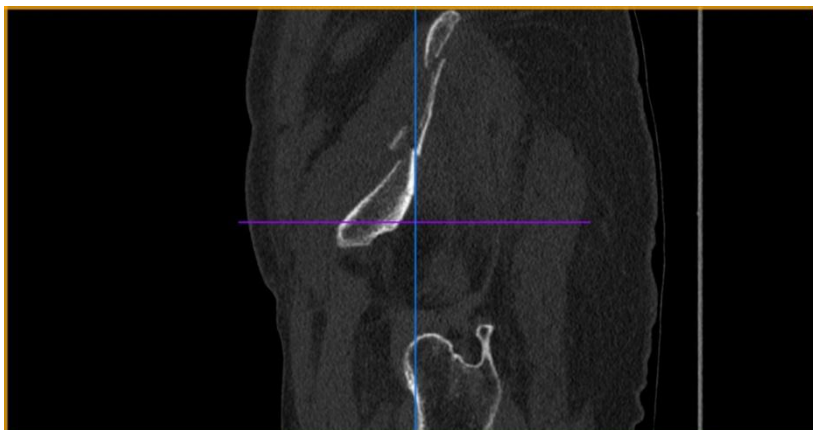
CT scan (axial section) reveals a compound fracture of the iliac wrist.
